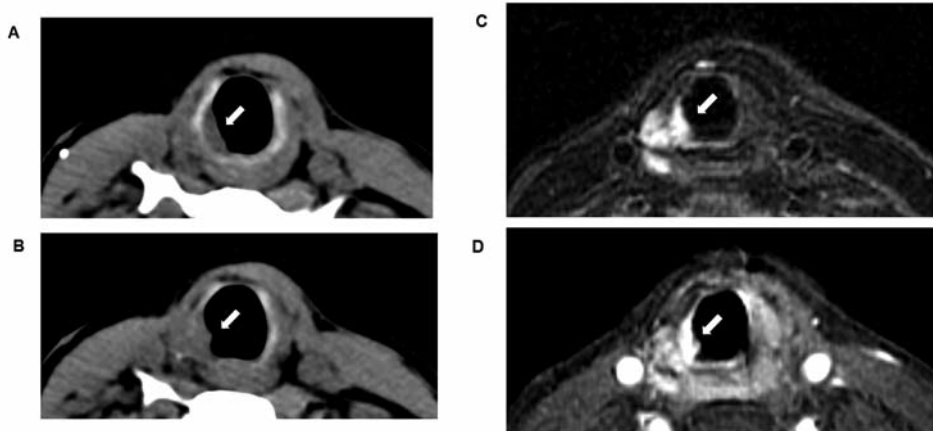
Neck imaging before Ptx/Cb CRT: A and B, Two consecutive axial pre contrast computed tomography images of the neck. There is an infiltrative lesion in the right subglottic area, abutting the luminal wall at the laryngotracheal border (arrows). Since the examination was performed without administration of i.v. contrast, the lateral margins of the tumor are not appreciated. C, Axial T2-weighted MRI scan of the neck with fat suppression: An abnormal mass measuring 1.0 cm in maximal diameter in the right paratracheal region is infiltrating the wall of the trachea (arrows). D, Axial post contrast T1-weighted scan of the neck at the same level. There is abnormal increase enhancement in the tumor (arrows). The part of the tumor that has infiltrated the tracheal wall enhances more intensely.
